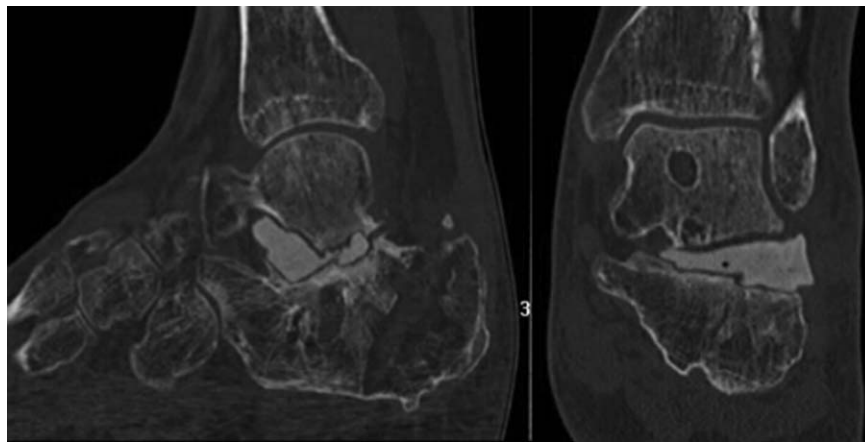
CT scan sagittal (left) and coronal (right) images showed antibiotic-impregnated PMMA bone cement placed within the subtalar space after debridement for infection.
